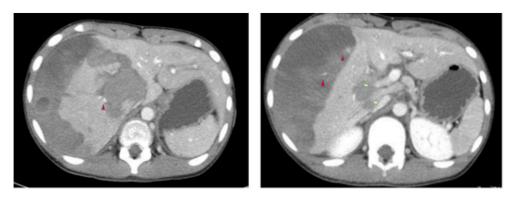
Findings of computed tomography scan on the day 3 of injury.
